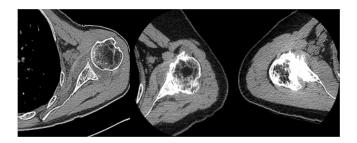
Two dimensional (2D) computed tomography (CT) scan shows a normal shoulder on the left and two pathologic shoulder on the right. The pathologic cases show a fusion area between the glenoid cavity and the humeral head.
